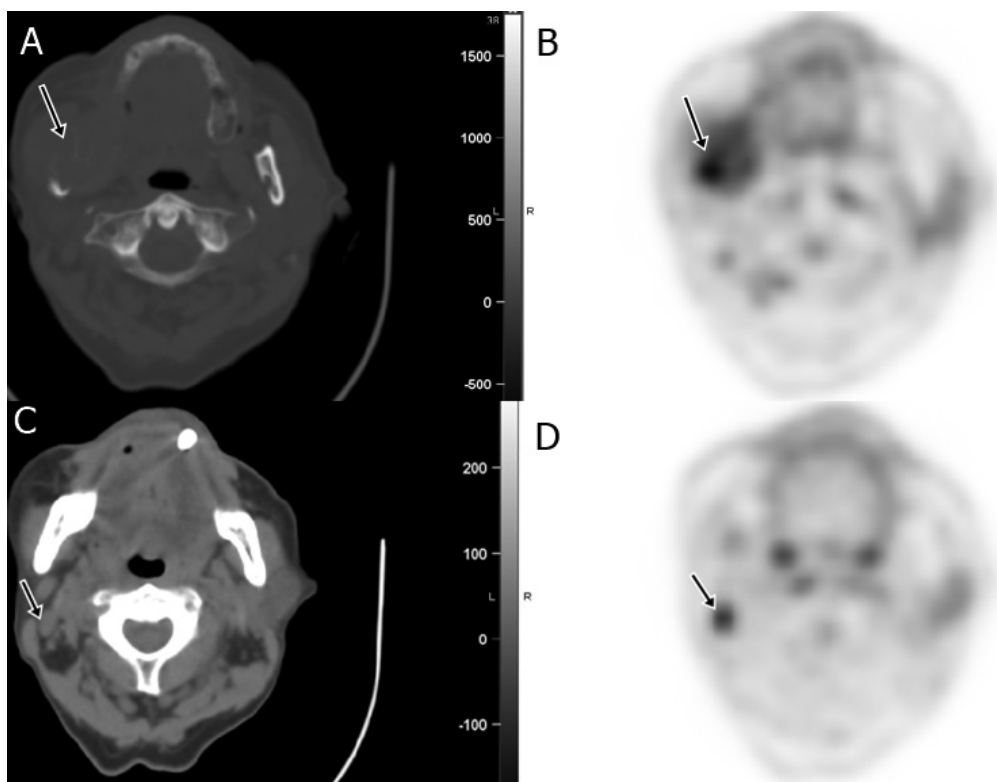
A 77-year-old man with newly diagnosed adenocarcinoma of the right mandible (patient 8). (A and B) Fluorodeoxyglucose PET/CT showed FDG avid destructive bone lesion with adjacent soft tissue invasion (arrows). The diagnostic CT did not report lymphadenopathy; however, (C and D) PET/CT showed a 1.1 cm level IIa lymph node with intense uptake (arrows). The neck dissection confirmed metastatic disease. PET, positron emission tomography.
